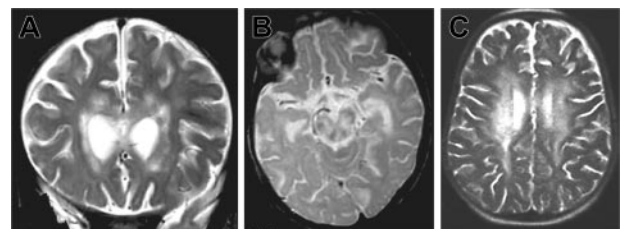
Brain magnetic resonance images of patients 1 and 2. MRIs show large white matter lesions in periventricular areas and brain stem. (A) Patient 1, 7 months, coronal T2 section. (B) Patient 1, 7 months, sagittal T2 section. (C) Patient 2, 33 months, sagittal T2 section.
